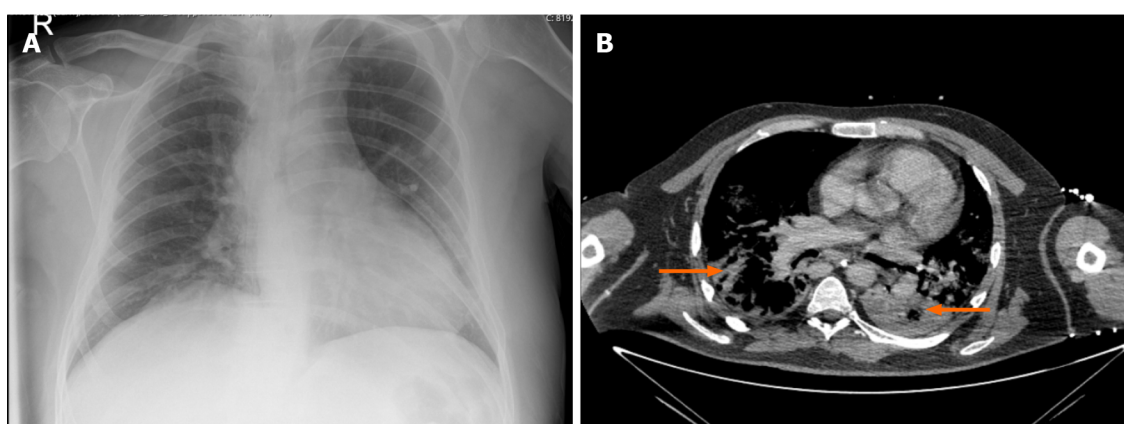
Case 2. A: The unremarkable chest radiograph at the time of admission; B: Computed tomographic pulmonary angiography showing evidence of bilateral coronavirus disease-19 pneumonia (arrows).
